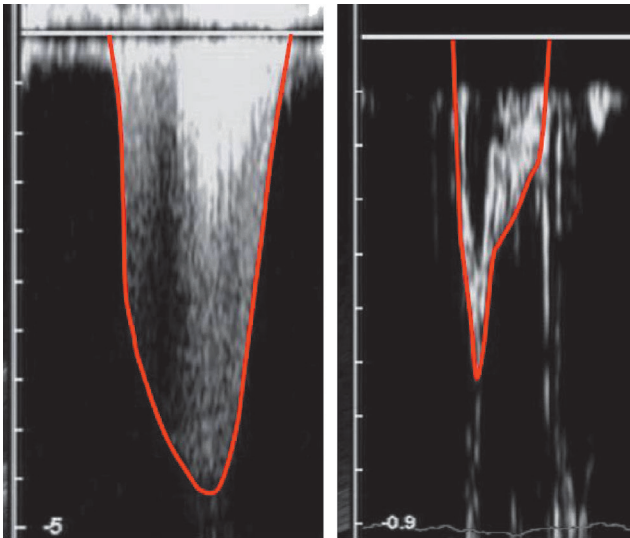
Example of Doppler regurgitant tricuspid (left) and pulmonary velocity (right). Red lines are plotted for a digitization purpose
